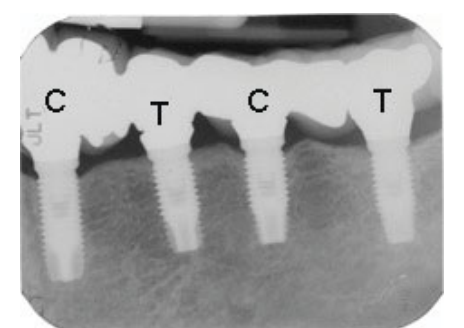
Periapical radiograph taken 6 years post implant placement (C=control, T= test).
